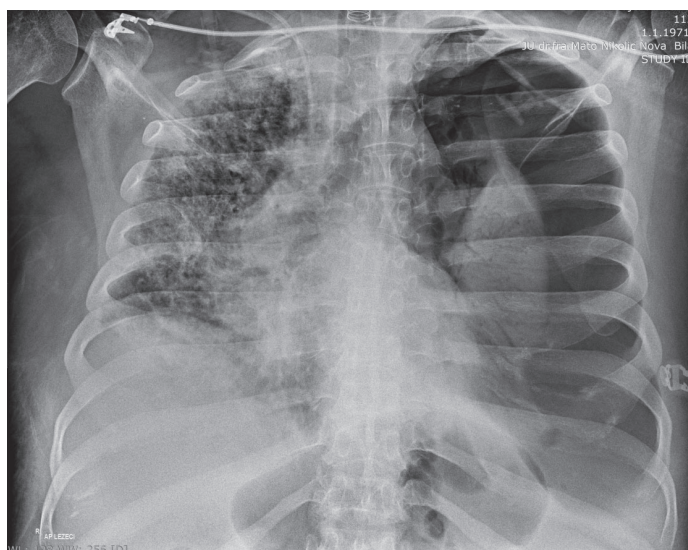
Radiograph of chest organs with pneumothorax (Source: Author)
